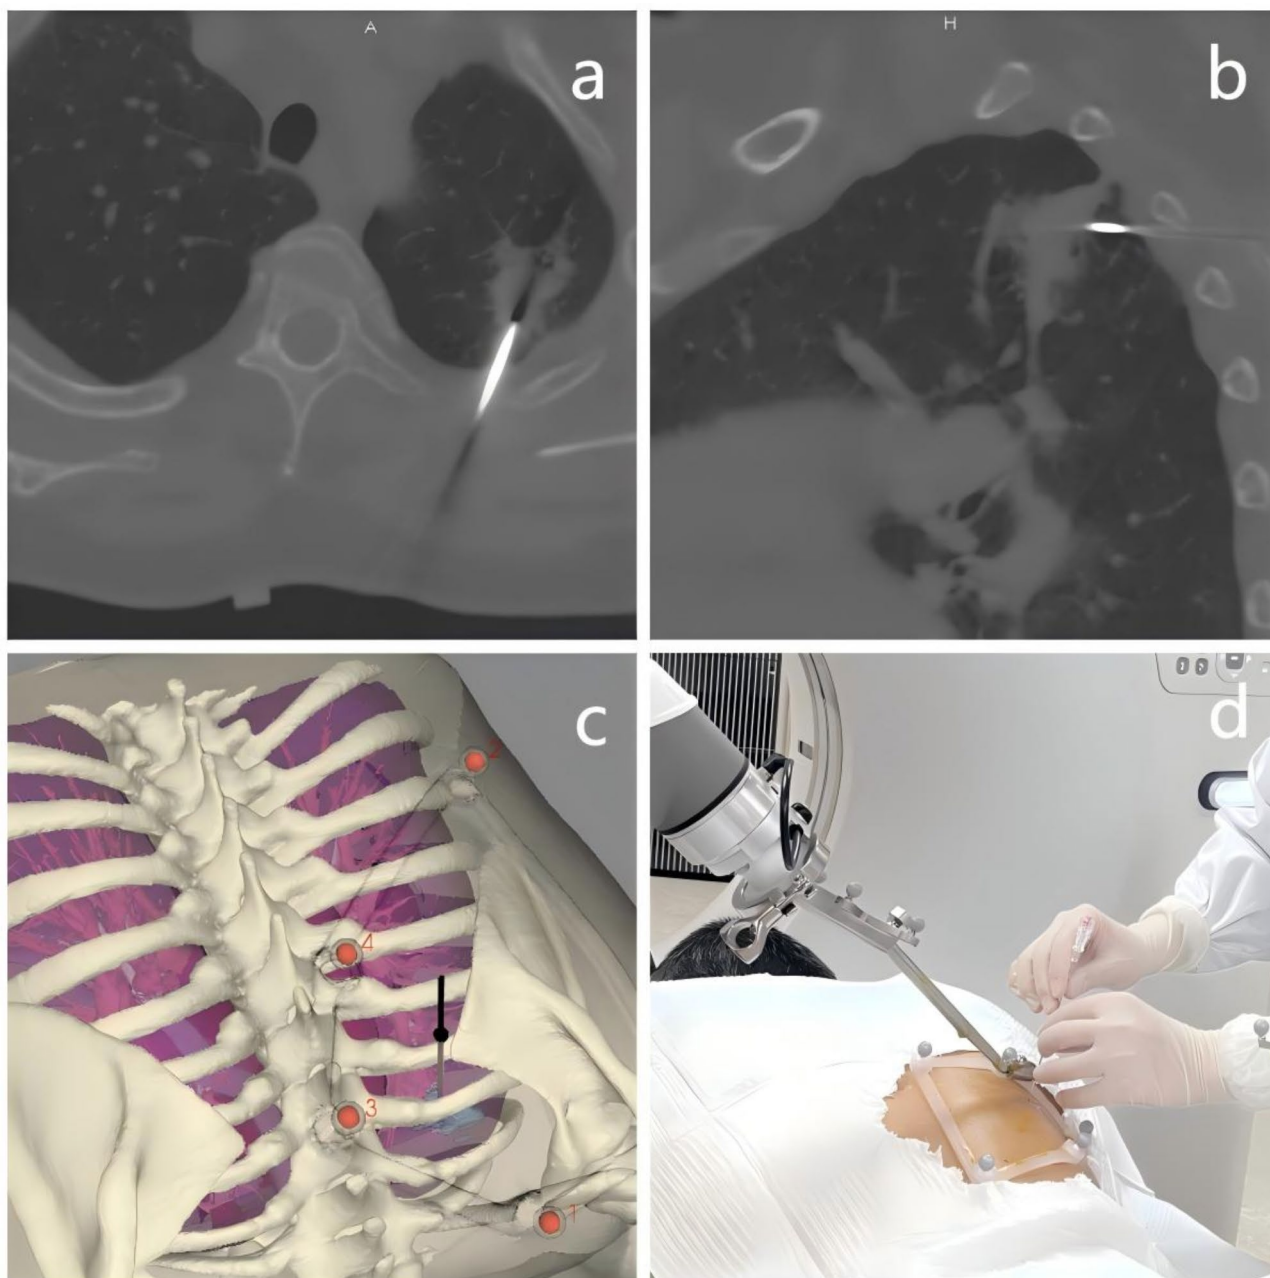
Example out-of-plane robotic assisted PTNB in a 61-year-old woman with a 14 mm solitary left upper lobe lesion. (a) Unenhanced axial CT image showing the out-of-plane puncture to the edge of the lesion. (b) Reconstructed sagittal CT image of the puncture in place. (c) 3D reconstruction of the thoracic structure and 3D verification of the puncture site. (d) photograph demonstrating the out-of-plane approach taken by the needle system.
